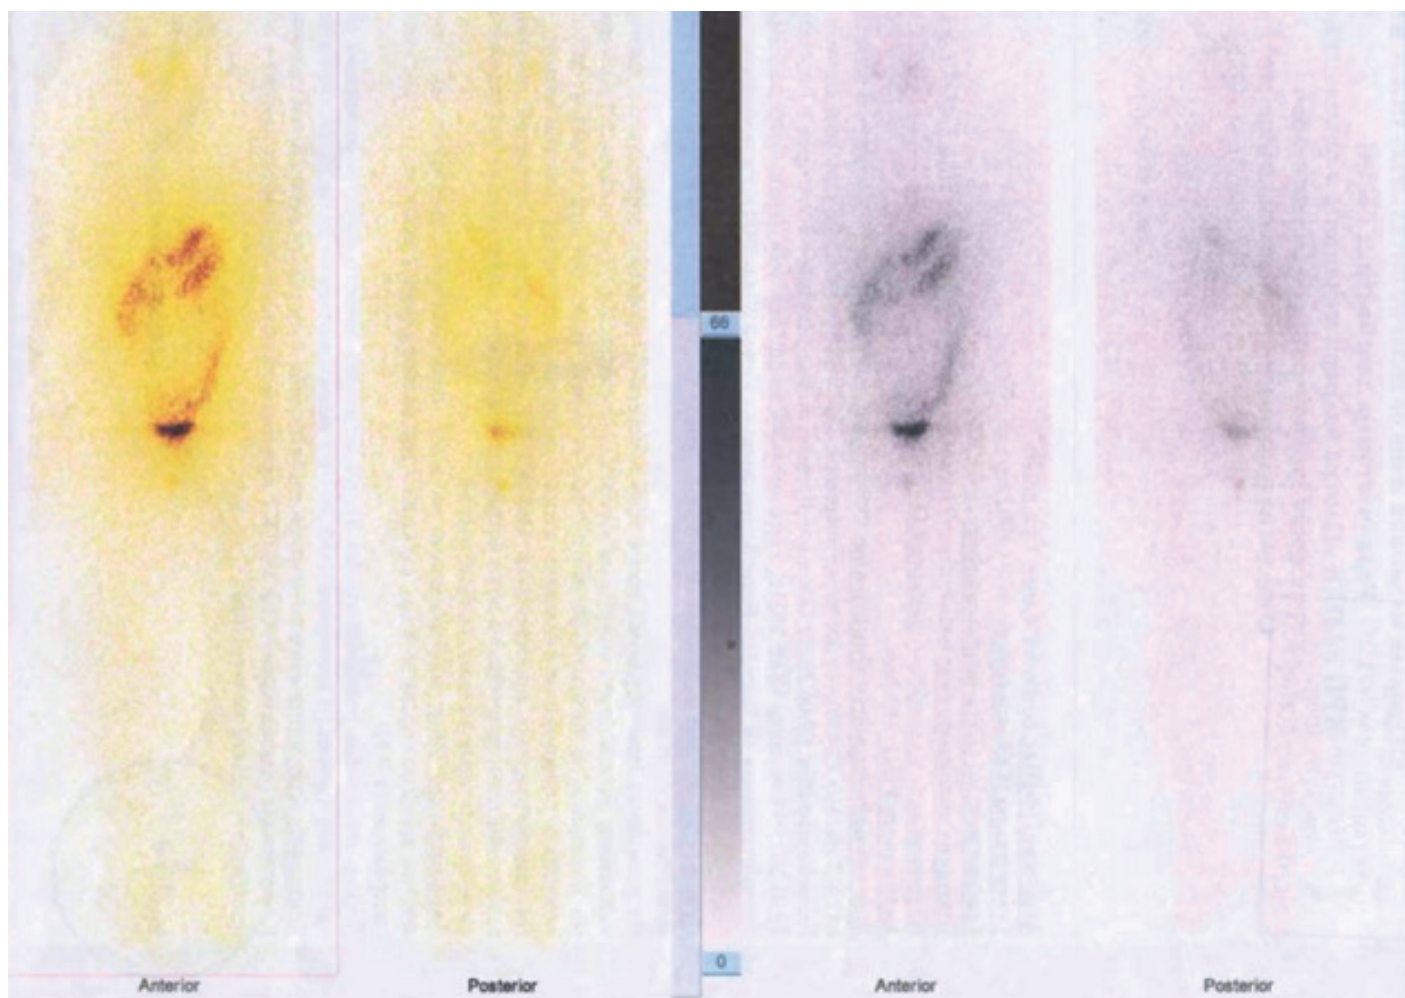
Conclusion of the SPECT: The focus of isotope accumulation in the area of the thyroid gland bed was not revealed
